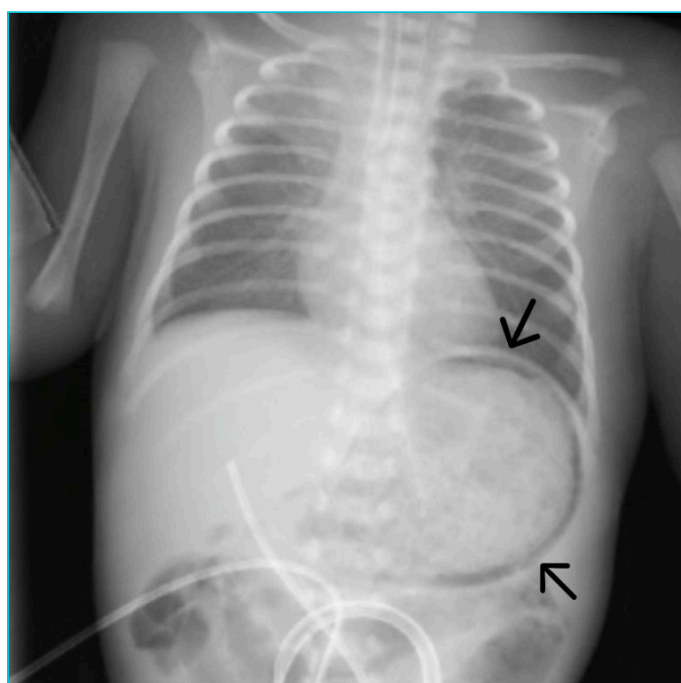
Gastric pneumatosis on direct abdominal radiograph taken on the second postnatal day
